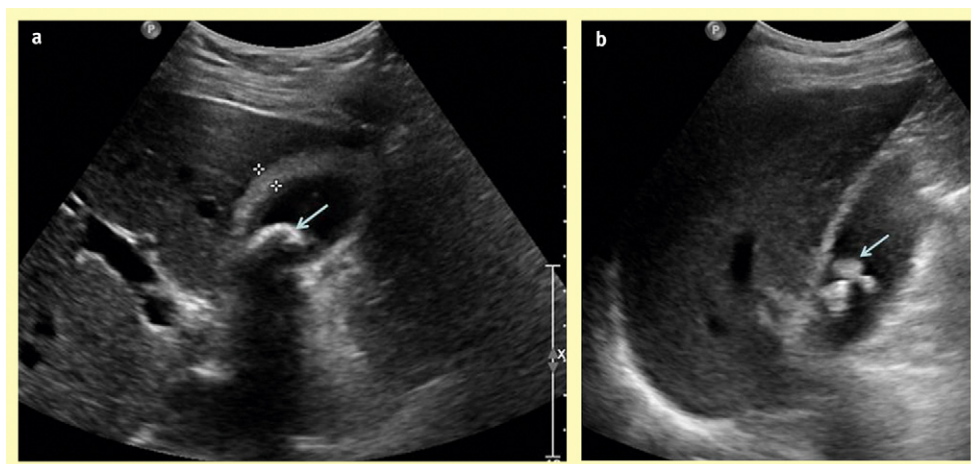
Acute cholecystitis with gallstone and acoustic shadow. Note the thickened wall () of the gallbladder and the acoustic shadowing caused by the gallstone (arrow). Not all stones cause a shadow on ultrasound as demonstrated in b (arrow).
